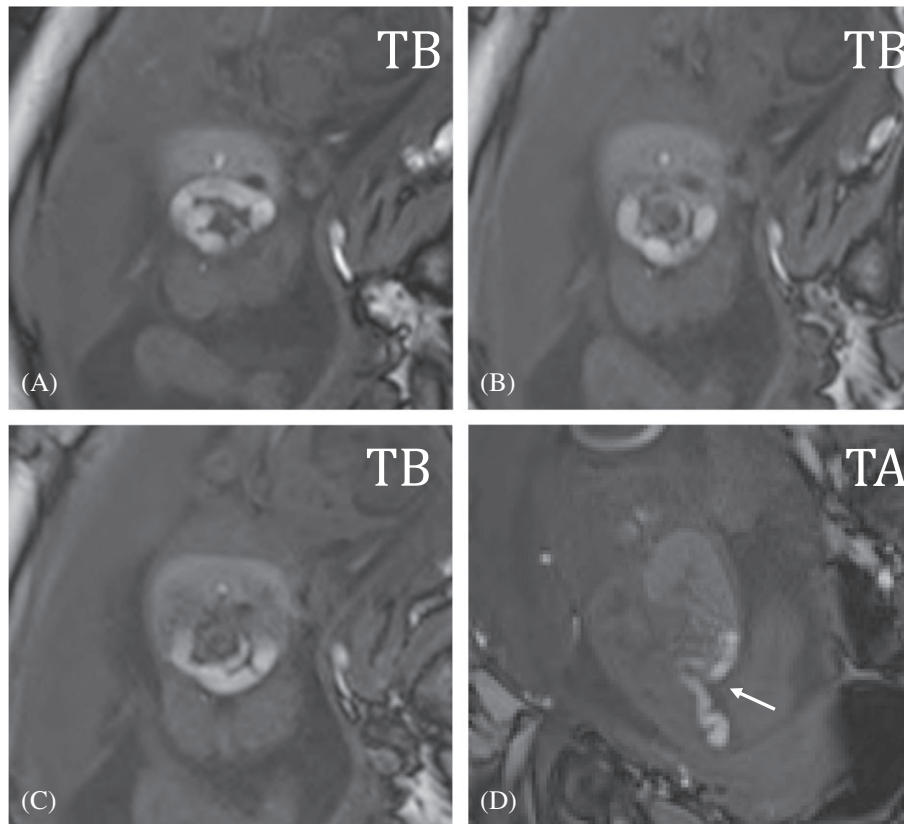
Case #9, 22–23 weeks of gestation. A, B, C, Dichorionic diamniotic twin pregnancy, twin B (case #9). MRI T1 weighted sequence coronal plane showing the volvulus of few bowel loops with hypersignal content (due to meconial and/or haemorrhagic content). D, Twin A (unaffected). Normal meconium pattern in the sigmoid and the rectum (→arrow) for comparison.
